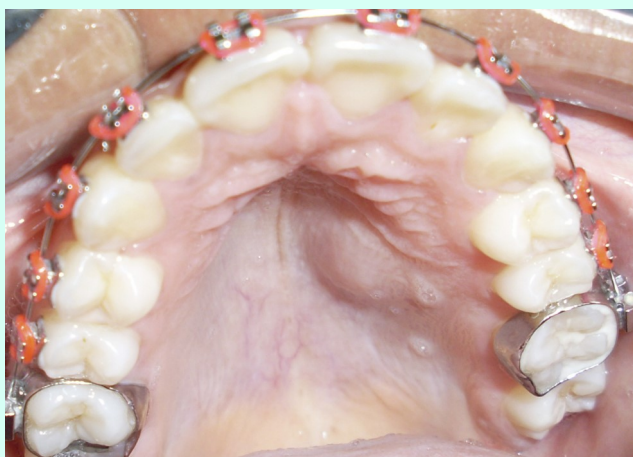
Lesion on the left palatal mucosa, in the periapical region of teeth 23, 24 and 25.
